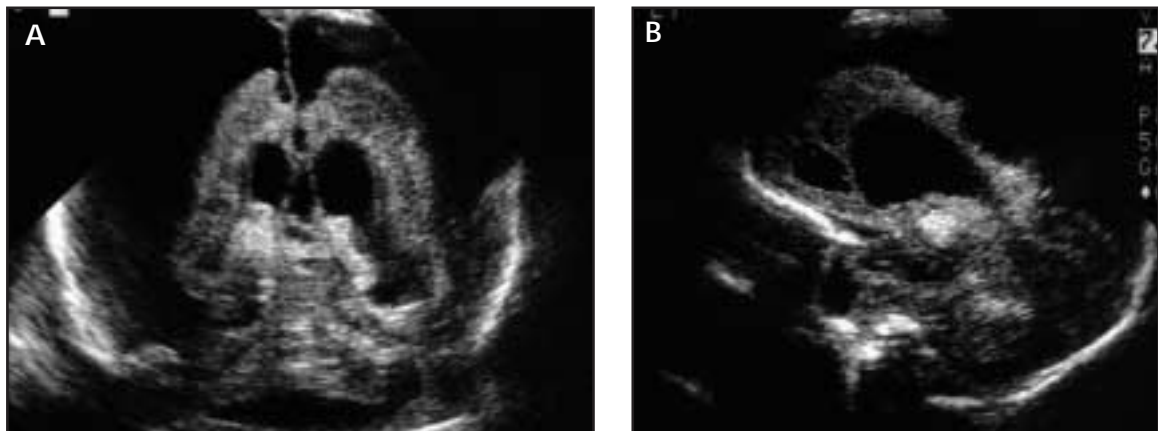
Neonatal cranial ultrasound images performed through the anterior fontanel in the (A) coronal plane and (B) sagittal plane demonstrate diffuse parenchymal volume loss with associated ventriculomegaly and large extra-axial fluid collections. Cystic parenchymal changes are also evident on the sagittal image (B).
